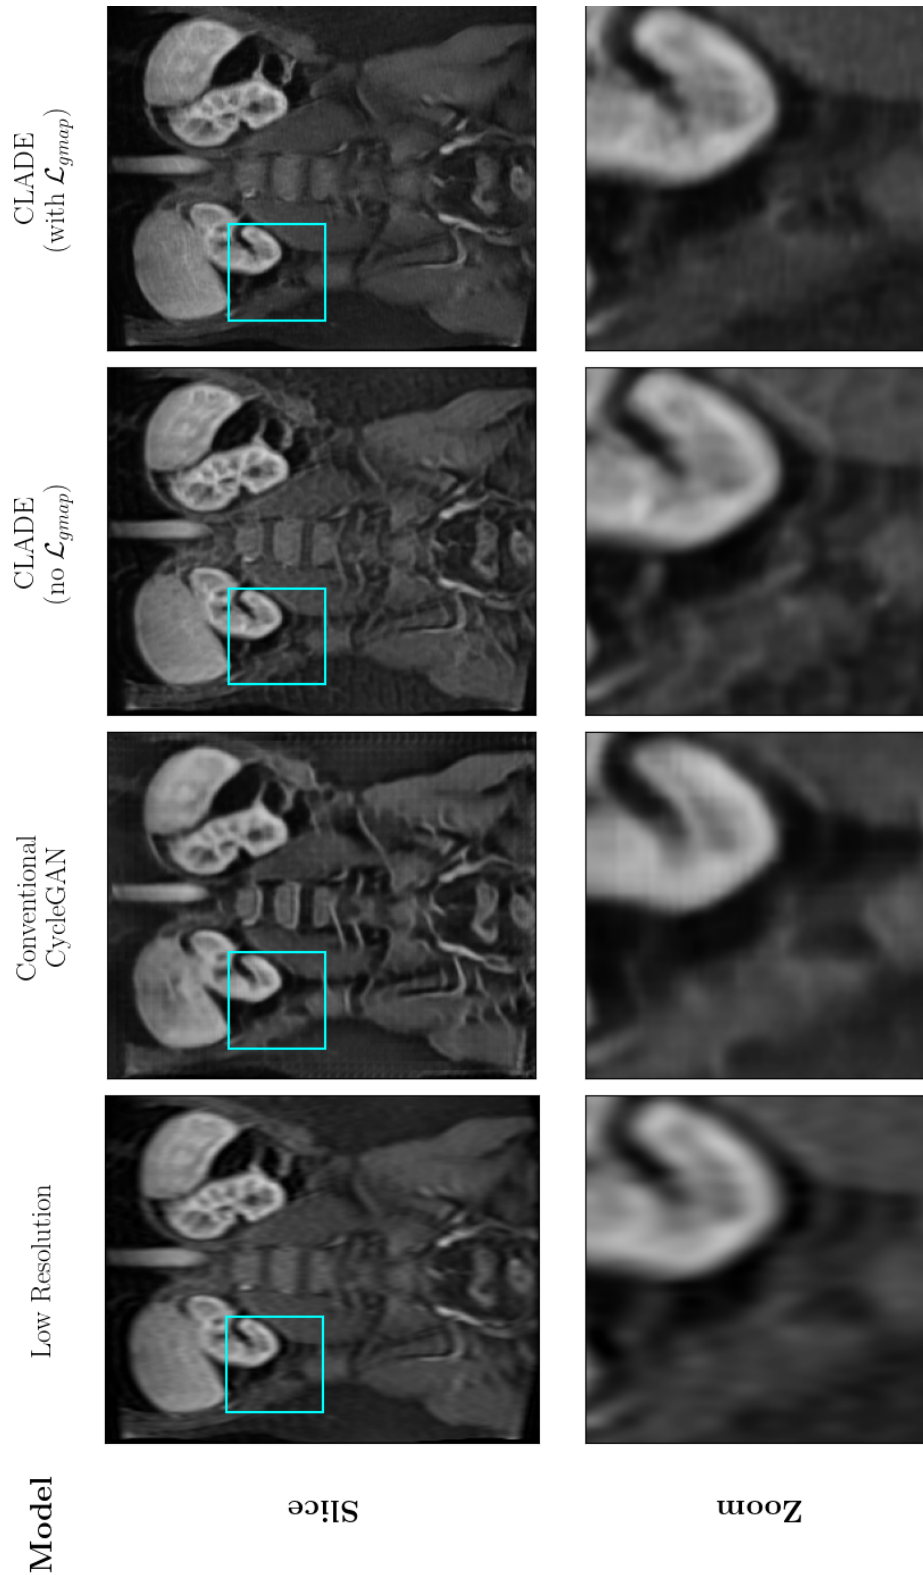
MRI paired networks, applied to paired data (coronal). Although there are some improvements to the resolution, the networks fail to faithfully reconstruct the original ground-truth high resolution images. It can clearly be seen that although resolution is marginally improved, the downsampling artifacts and degradations still remain present in the reconstructions.
